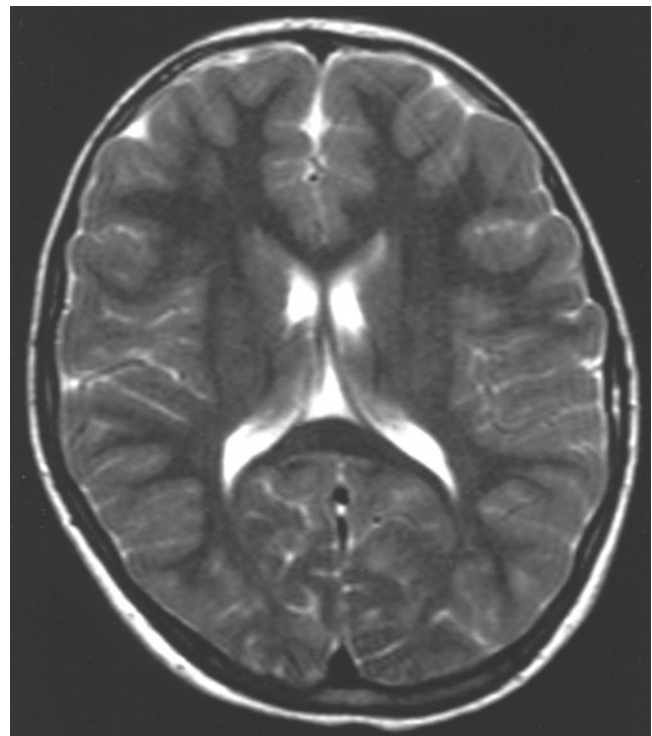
Axial T₂-weighted TSE (4530/100) magnetic resonance image shows normal brain findings.
